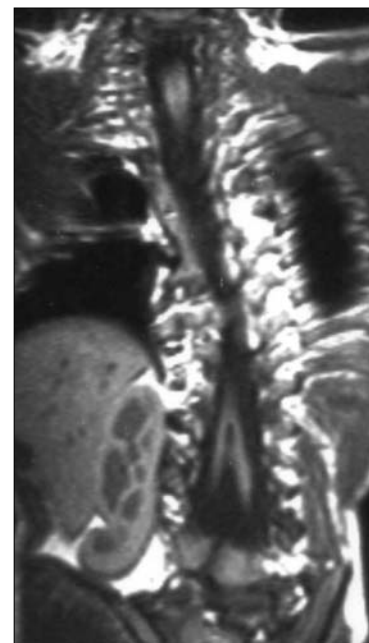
Coronal precontrast T1 weighted MR image shows the two hemicords clearly.
